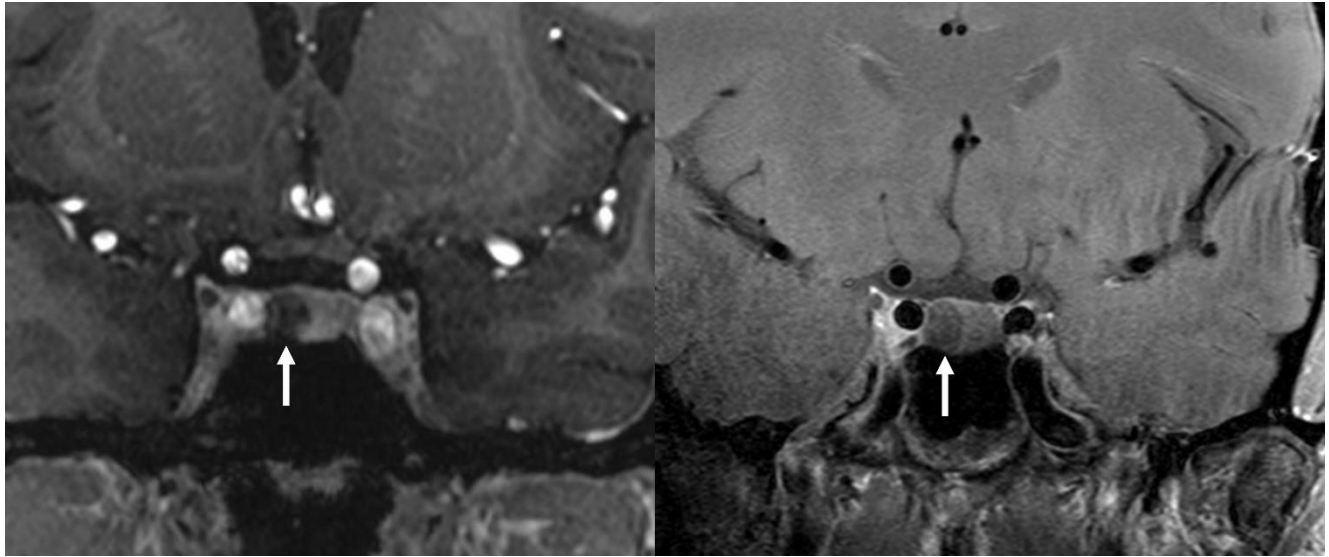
7T postcontrast T1-weighted imaging in a patient with a right sided pituitary adenoma. The left image is a 3D MPRAGE sequence while the right image is a 2D turbo-spin echo sequence. The MPRAGE image demonstrates greater contrast between the normally enhancing pituitary compared to the hypoenhancing adenoma.
